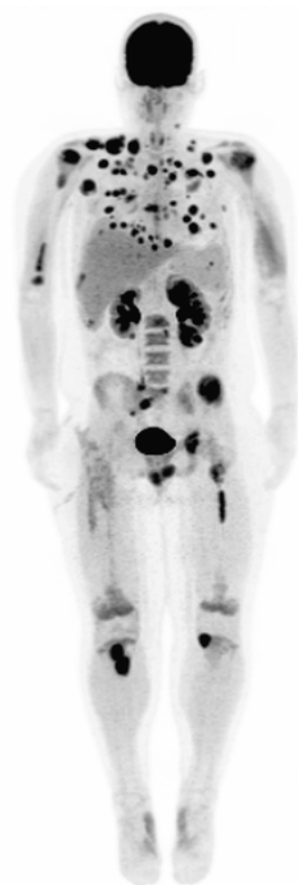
This whole-body maximum intensity projection F^{18} -fluorodeoxyglucose (FDG) positron emission tomography image reveals extensive metastatic disease from adrenocortical carcinoma evidenced as innumerable foci of FDG avidity, throughout the lungs and bones and in lymph nodes
